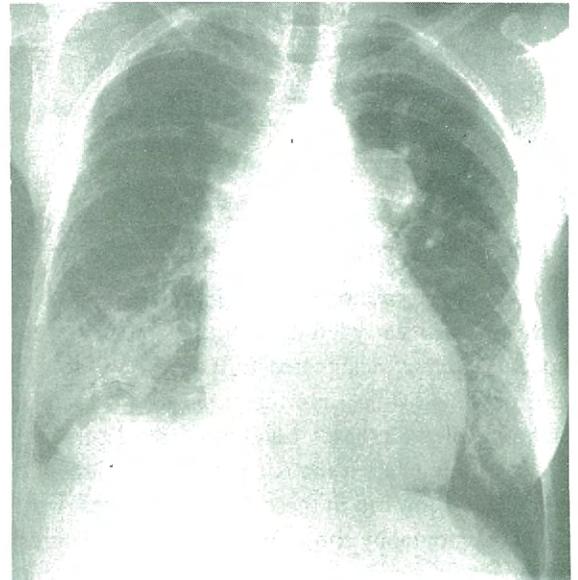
Chest x-ray from a patient with PAVF (case 2) showing angiomatoid malformations in the right lower lobe.
